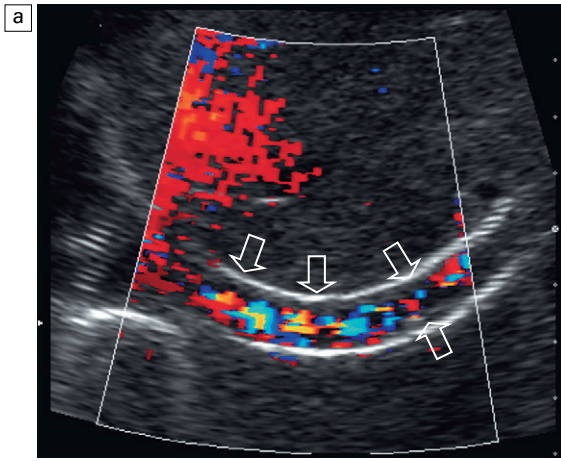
Spectral and colour Doppler image at the hepatic vein end of the TIPS catheter. Note on the colour image that the catheter ends well short of the inferior vena cava. The diameter of the hepatic vein above the TIPS is relatively narrow (arrow). The spectral Doppler tracing shows a velocity of 2.5 m s^{-1} . This high velocity jet is due to the focal stenosis due to the hypertrophy bar of tissue.
